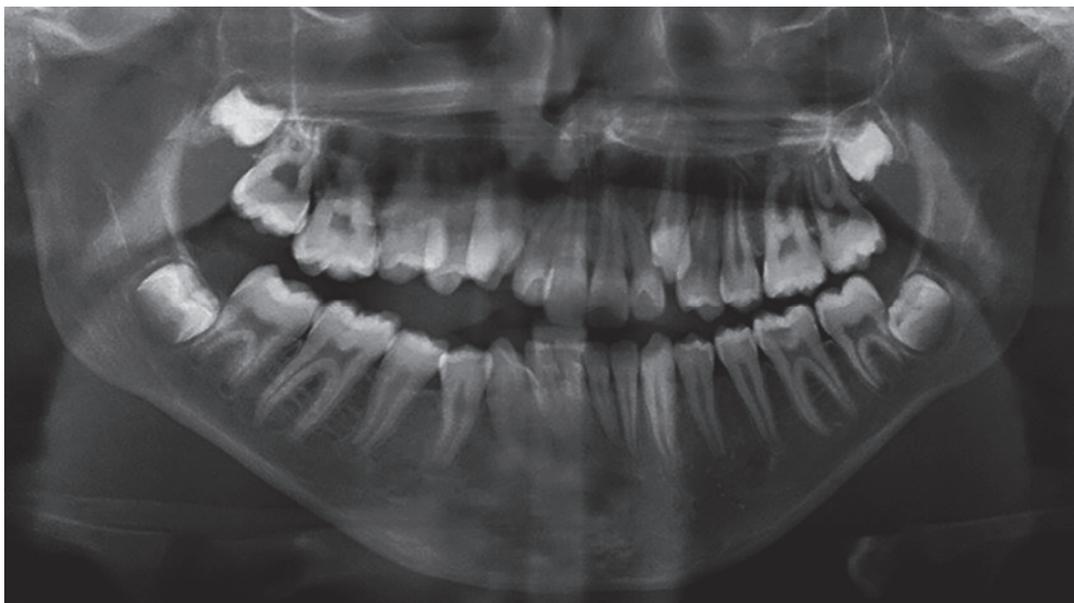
Panoramic radiograph before therapy.
